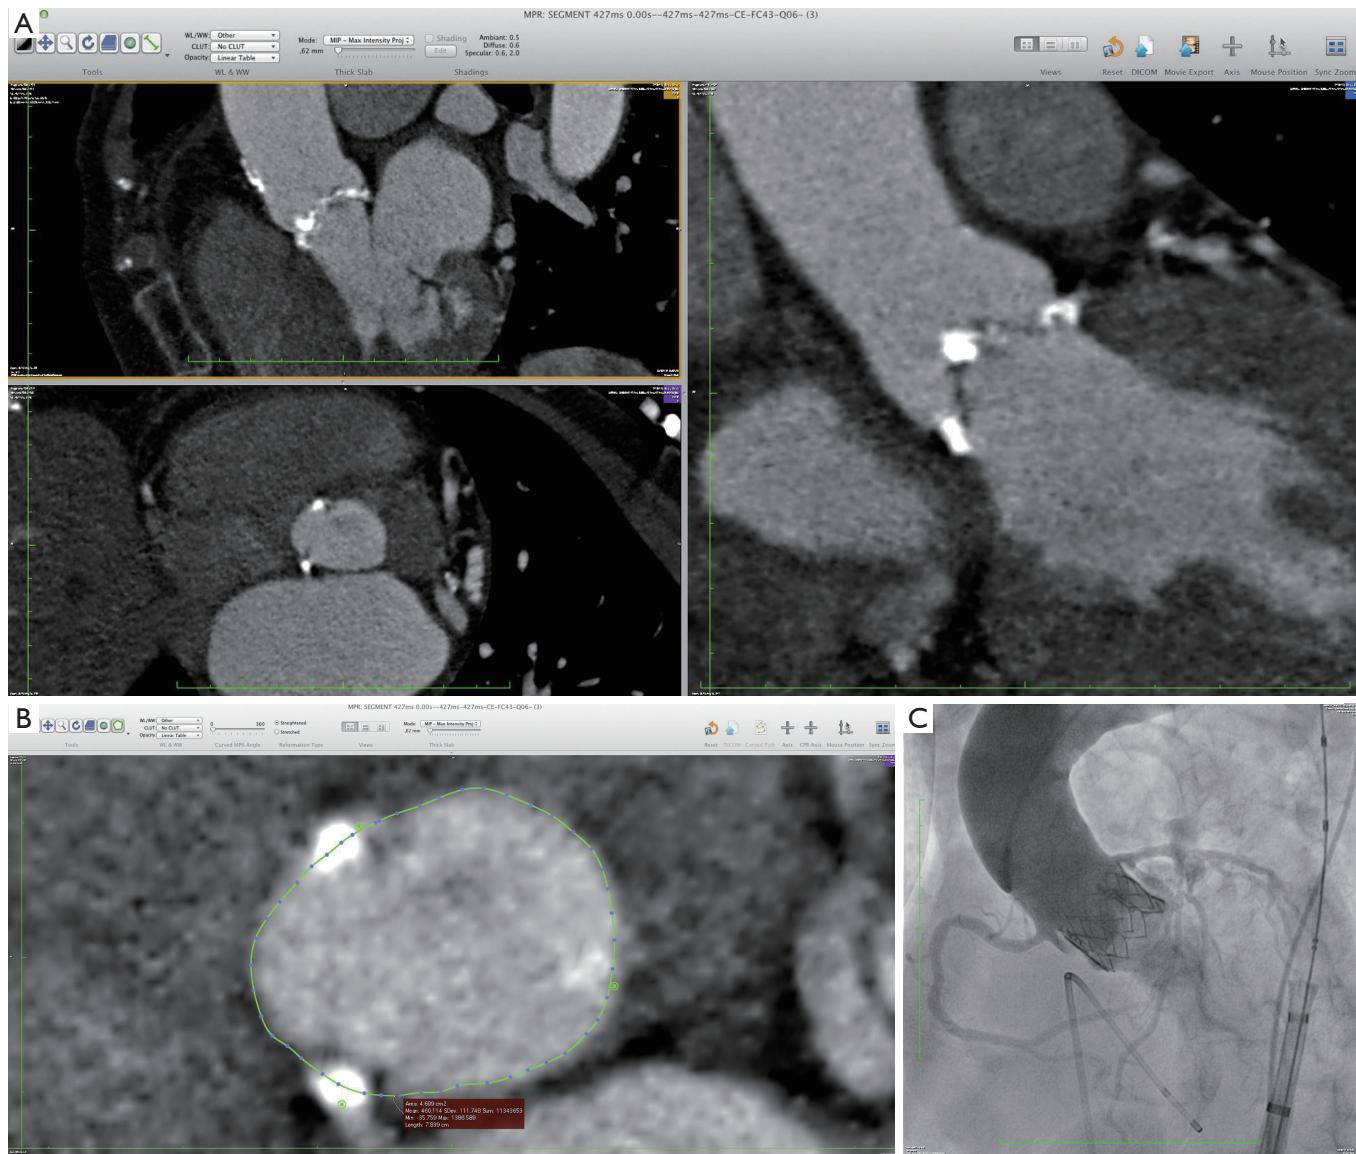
A. An 86 years old lady with multiple comorbidities was addressed? To our TAVI program. At echocardiography, the annulus was 23 mm. MDCT demonstrated the presence of a heavily calcified, markedly elliptical annulus (29.5×21.1 mm at the level of the virtual basal ring); B. The area of the virtual ring was 4.7 cm² and the circumference was 7.84 cm. The resulting average diameter was 24.4/24.9 mm, respectively. The decision was taken to implant a 26 mm Edwards Sapien valve percutaneously; C. After the valve deployment, the patient developed refractory hypotension. The aortography demonstrated leakage of contrast medium into the pericardium and echocardiography showed cardiac tamponade. At the emergency surgical exploration the diagnosis of annular rupture was made
